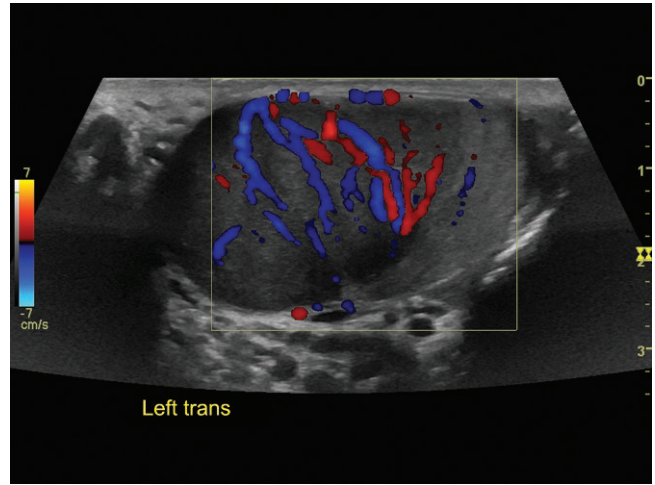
Color Doppler ultrasound demonstrates increase vascularity of the mass.
